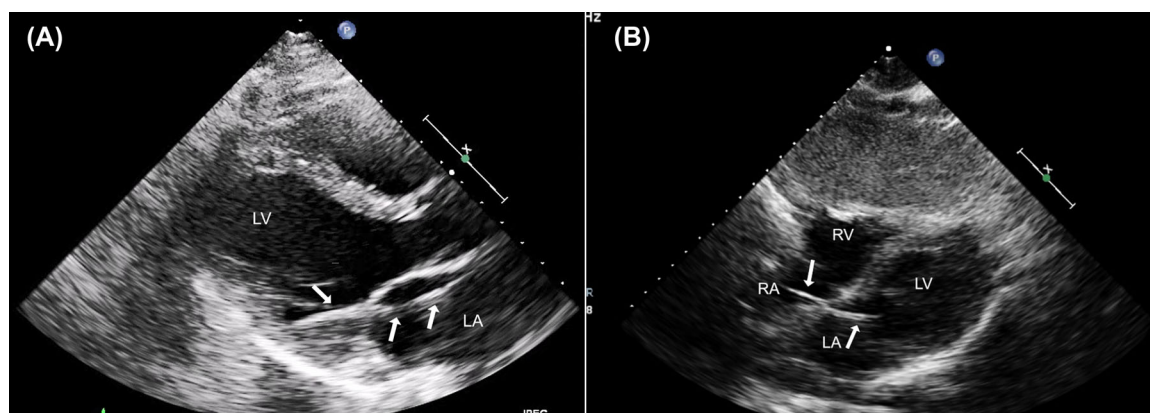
Echocardiographic left parasternal view and subcostal view showing a pacing lead (arrows) originating from the RA crossing the atrial septum and mitral valve embedded into the lateral LV wall. LA, Left atrium; LV, Left ventricle; RA, Right atrium; RV, Right ventricle [Color figure can be viewed at wileyonlinelibrary.com]
